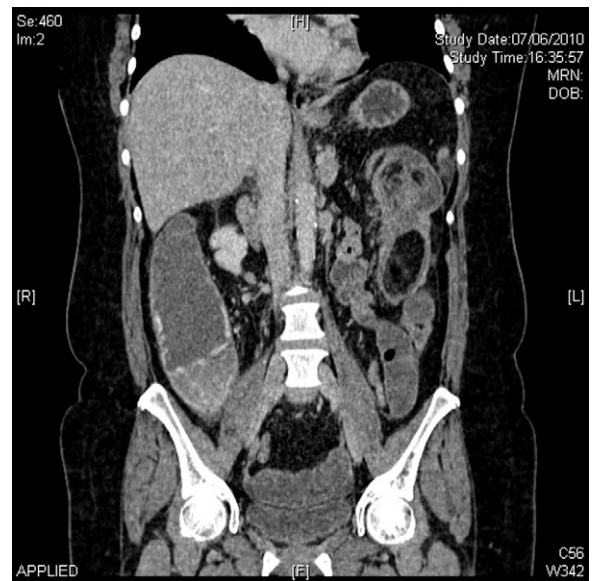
Coronal CT scan of colo-colonic intussusception secondary to lipoma.
